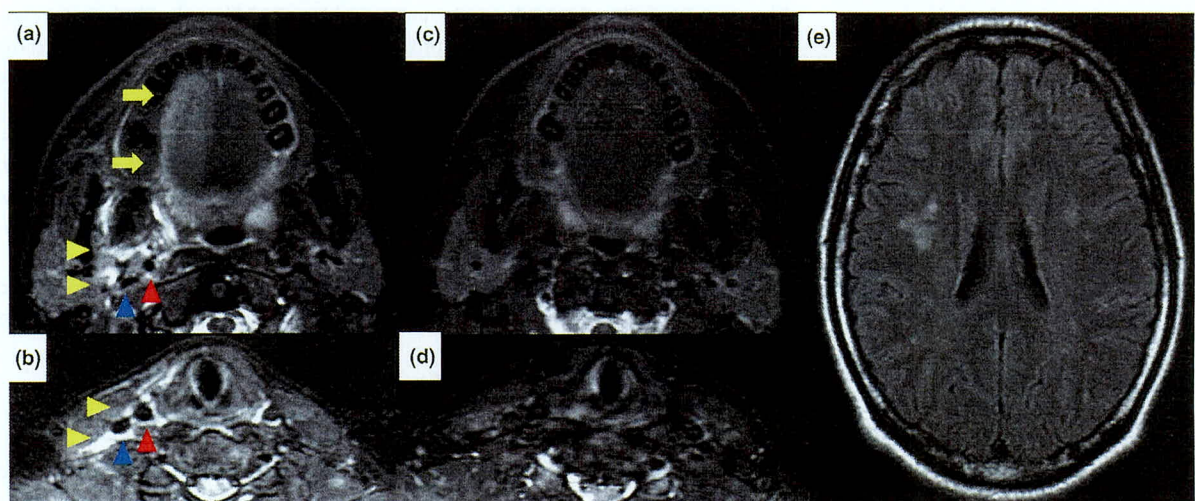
(a,b) Magnetic resonance imaging showed a high-intensity area with contrast effect spreading in the retroparotid space (yellow arrowhead) around the right carotid artery (red arrowhead) and internal jugular vein (blue arrowhead), and a high-intensity area was also confirmed in the right tongue (arrow) in the short T1 inversion recovery image. (c,d) The abnormal signal area of the magnetic resonance image in the right side of the tongue and retroparotid space disappeared 6 months after treatment. (e) A high-intensity area spreading in the deep gray matter of the cerebrum on the fluid-attenuated inversion recovery image.
